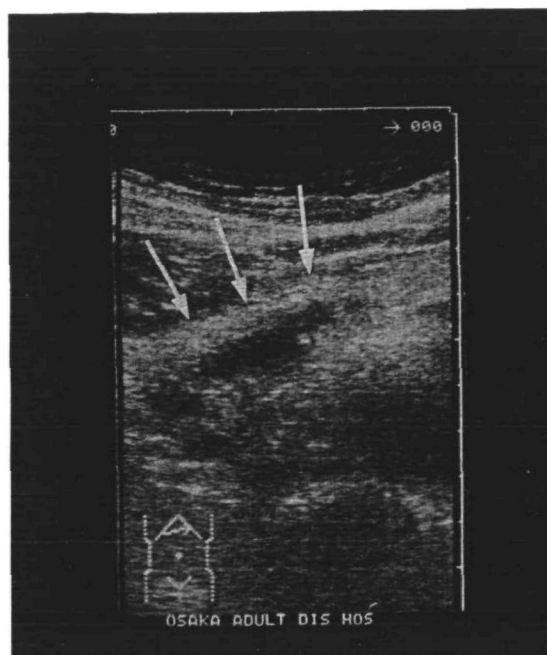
Longitudinal pancreatic sonogram of a true positive case. A dilated (5 mm) pancreatic duct (arrow heads) is shown running through the middle of the hyperechoic pancreas (arrows). Though no focal lesion was detected by any imaging modalities, a cytologic examination of the pure pancreatic juice showed positivity for cancer. Following the intraoperative cytodiagnosis, ductal adenocarcinoma located in the head was resected.¹⁸⁾
